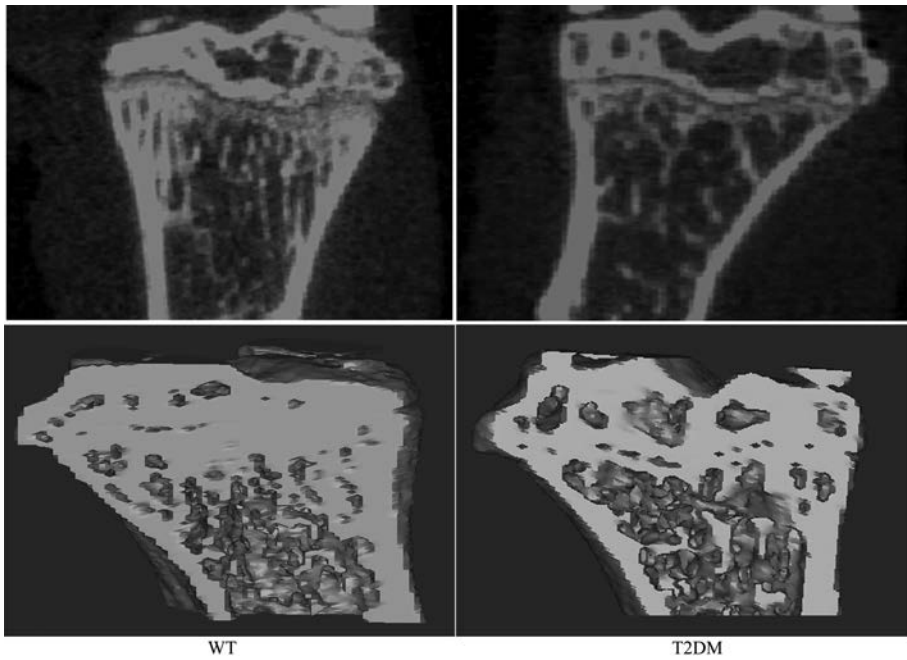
2 组胫骨平台处 CT 三维重建图像比较
